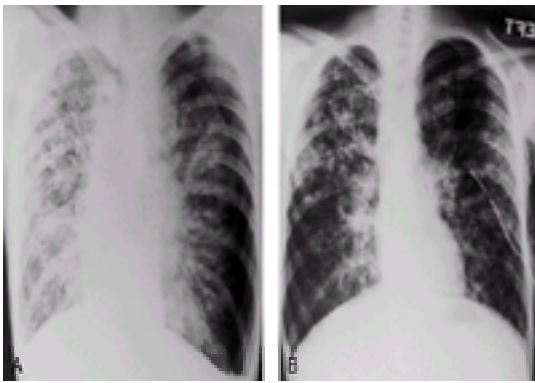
A. Chest roentgenogram showing a large left-sided pneumothorax with some shift of mediastinal structures of the right. B. Reexpansion of the left lung after tube thoracostomy and suction.
